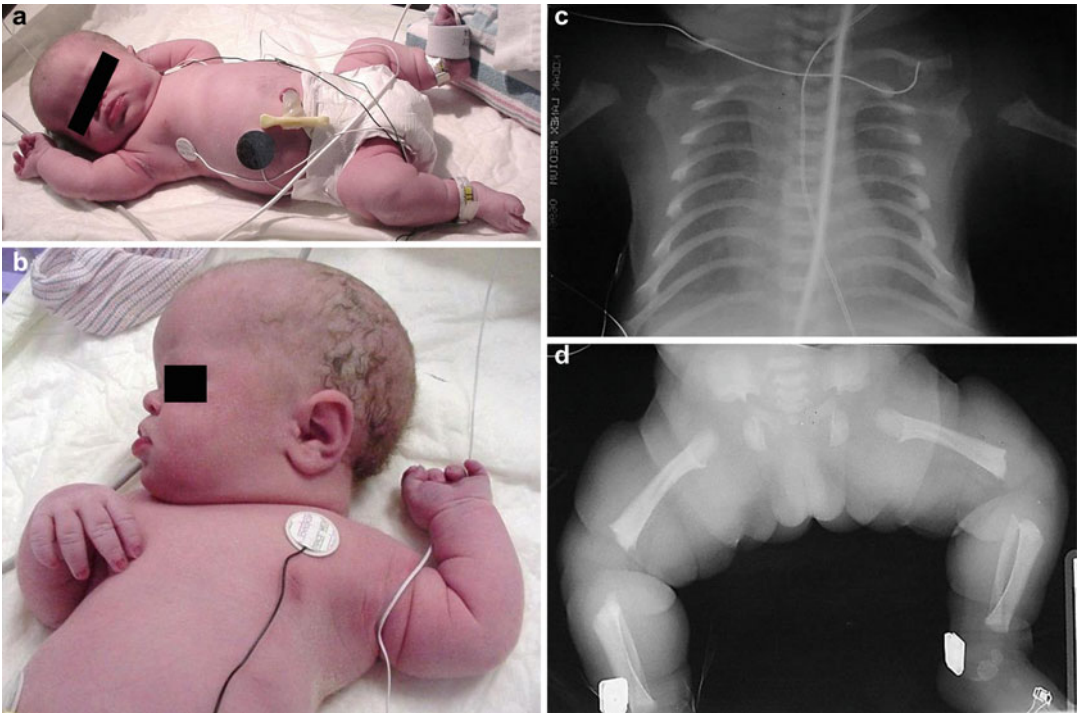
A newborn with achondroplasia showing large head, depressed nasal bridge, short neck, normal length of the trunk, narrow chest, rhizomelic micromelia, and trident hands (a, b). The radiographs showed narrow chest, characteristic pelvis, micromelia, and oval
